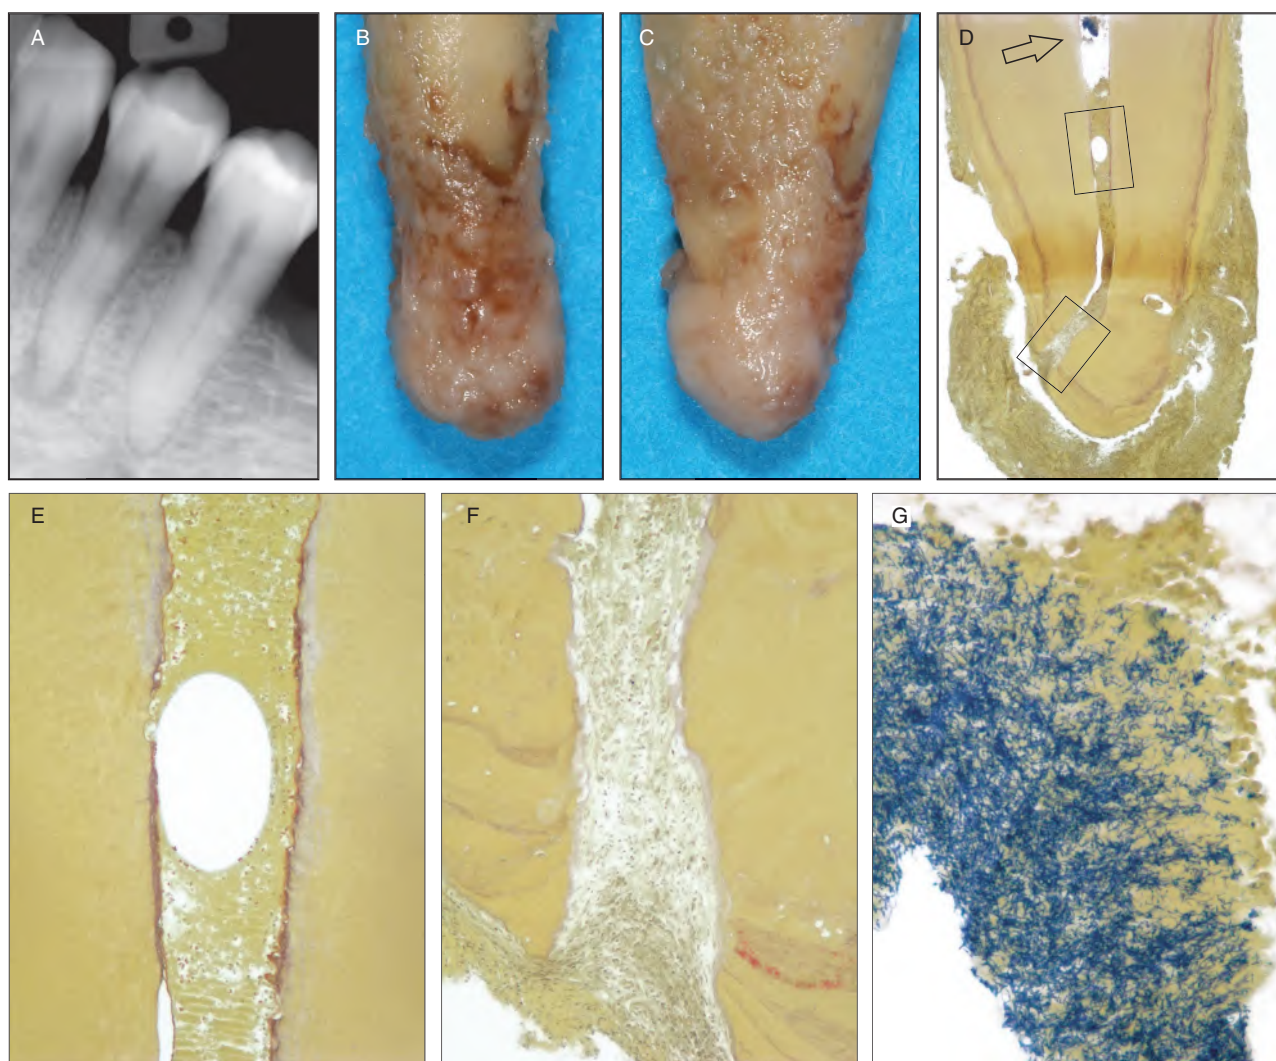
Mandibular first premolar of a 52-year-old woman with cervical caries and clinically necrotic pulp. A. Radiograph showing apical radiolucency associated with the tooth. Despite the tooth being treatable, the patient requested extraction. B and C. The apical periodontitis lesion remained attached to the apex at extraction. Buccal and mesial views. D. Section encompassing the root canal and one apical ramification. A second foramen can be seen on the opposite side of the apex. Note that the tissue in the most apical part of the left ramification is not necrotic. The apparently empty space between the pathologic tissue and the apex is a surgical artifact (Taylor's modified Brown and Brenn, original magnification $\times 16$). E. Magnification of the area demarcated by the upper rectangle in D. A microabscess is present in a disintegrated tissue ($\times 100$). F. Magnification of the area demarcated by the lower rectangle in D. Non-infected vital tissue is present in the ramification ($\times 100$). G. High power view of the area indicated by the arrow in D. Necrotic tissue heavily infected ($\times 400$).
